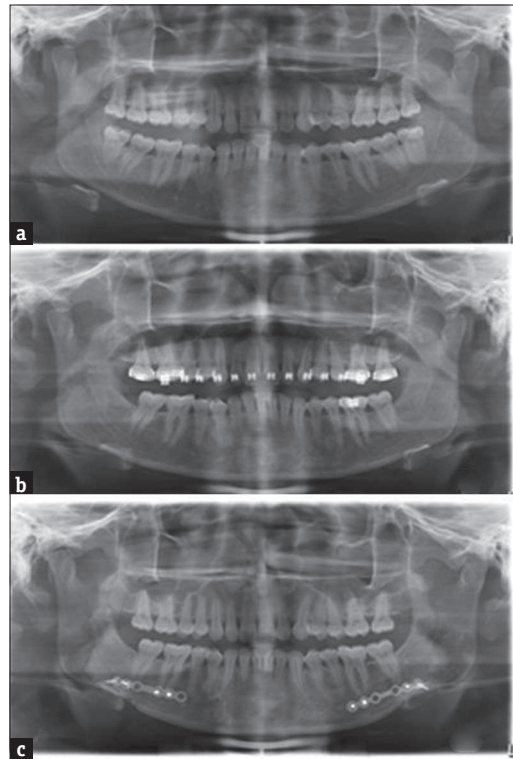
(a) Pretreatment orthopantomogram, (b) presurgical orthopantomogram, (c) posttreatment orthopantomogram
